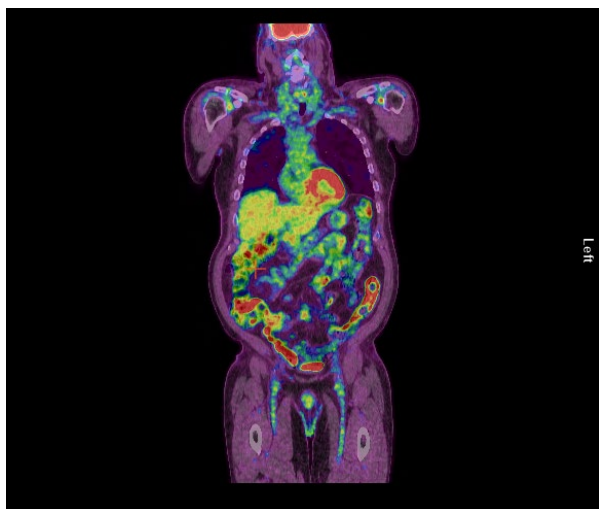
Coronal fused FDG PET/CTs of patients with mild (NIBU=1, top image) and moderate-to-high (NIBU=7, bottom image) degree of FDG-intense bowel uptake heterogeneity.
